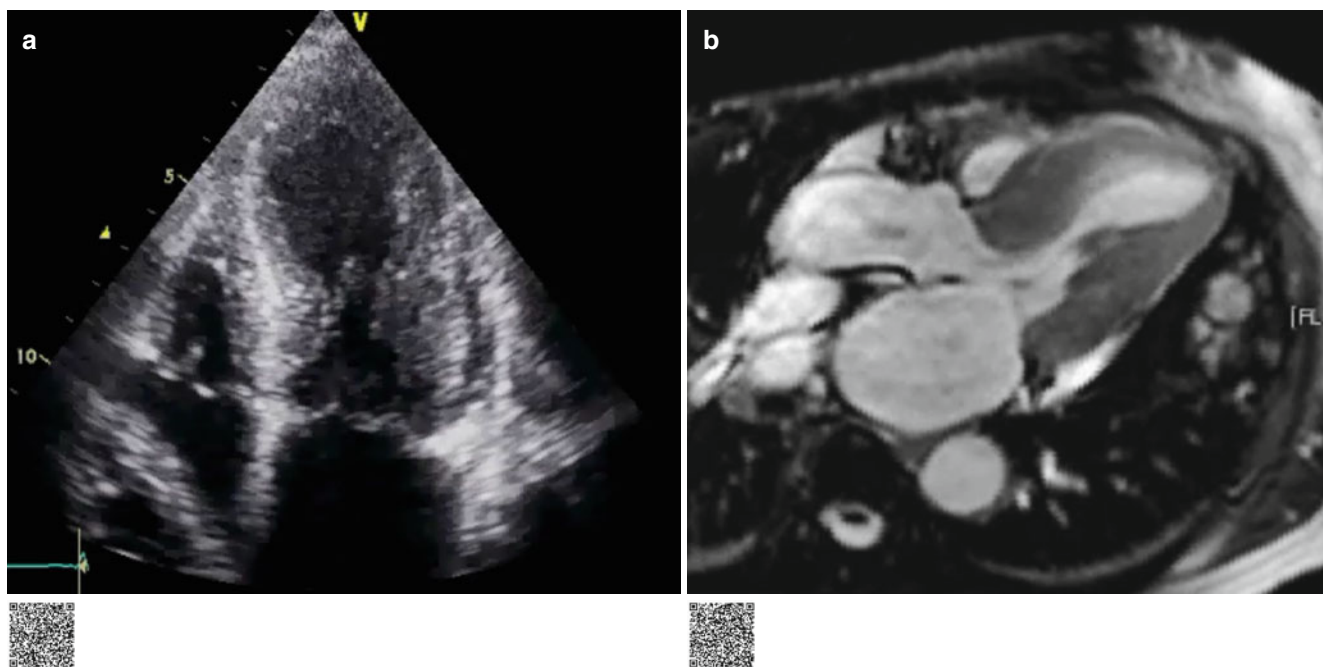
Echocardiography and MRI of a patient with stress cardiomyopathy. Horizontal long-axis cine images (a) (<http://extras.springer.com/2015/978-3-642-36396-2>) on echocardiography and (b) (<http://extras.springer.com/2015/978-3-642-36396-2>) cine MR image show
